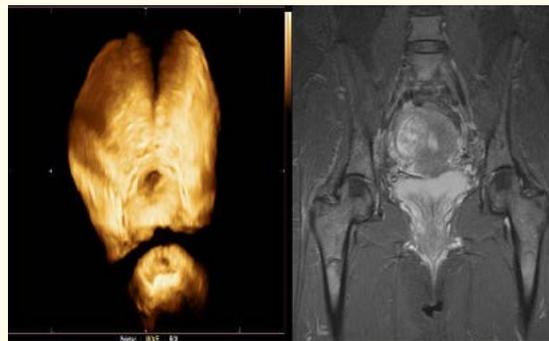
Image (A) is 3Dimension ultrasound (3DUS), that shows torn IUS with an open urethra, especially its upper end with funneling of the bladder neck. Image (B) is an MR image, which shows torn IUS, the lacerations affect the whole length.
